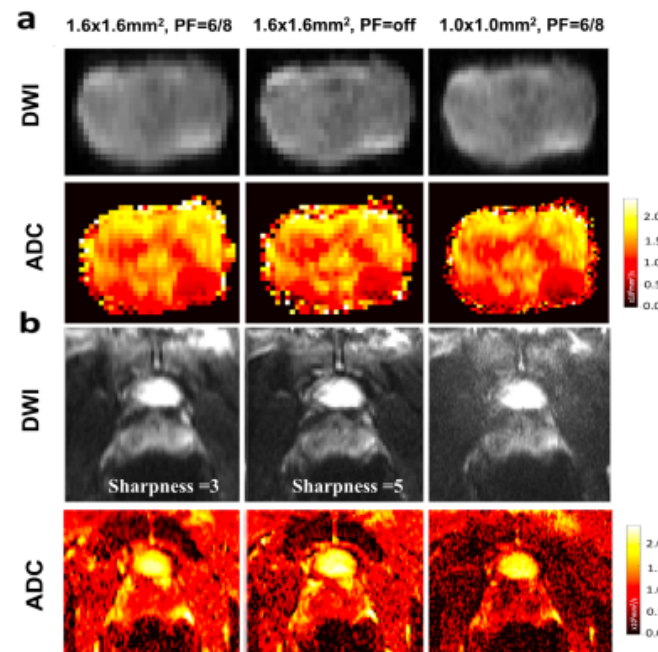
a) Ex-vivo prostate ENCODE DWI using standard- and higher-resolution protocols (top). Corresponding ADC maps (bottom). b) In-vivo prostate ENCODE DWI using standard- and higher-resolution protocols (top). Corresponding ADC maps (bottom). The sharpness scores are labeled in the images and both have contrast score of 4. The higher-resolution ENCODE DWI protocol ($1.6 \times 1.6\text{mm}^2, PF=off$) achieved the highest image quality scores for sharpness and contrast.
